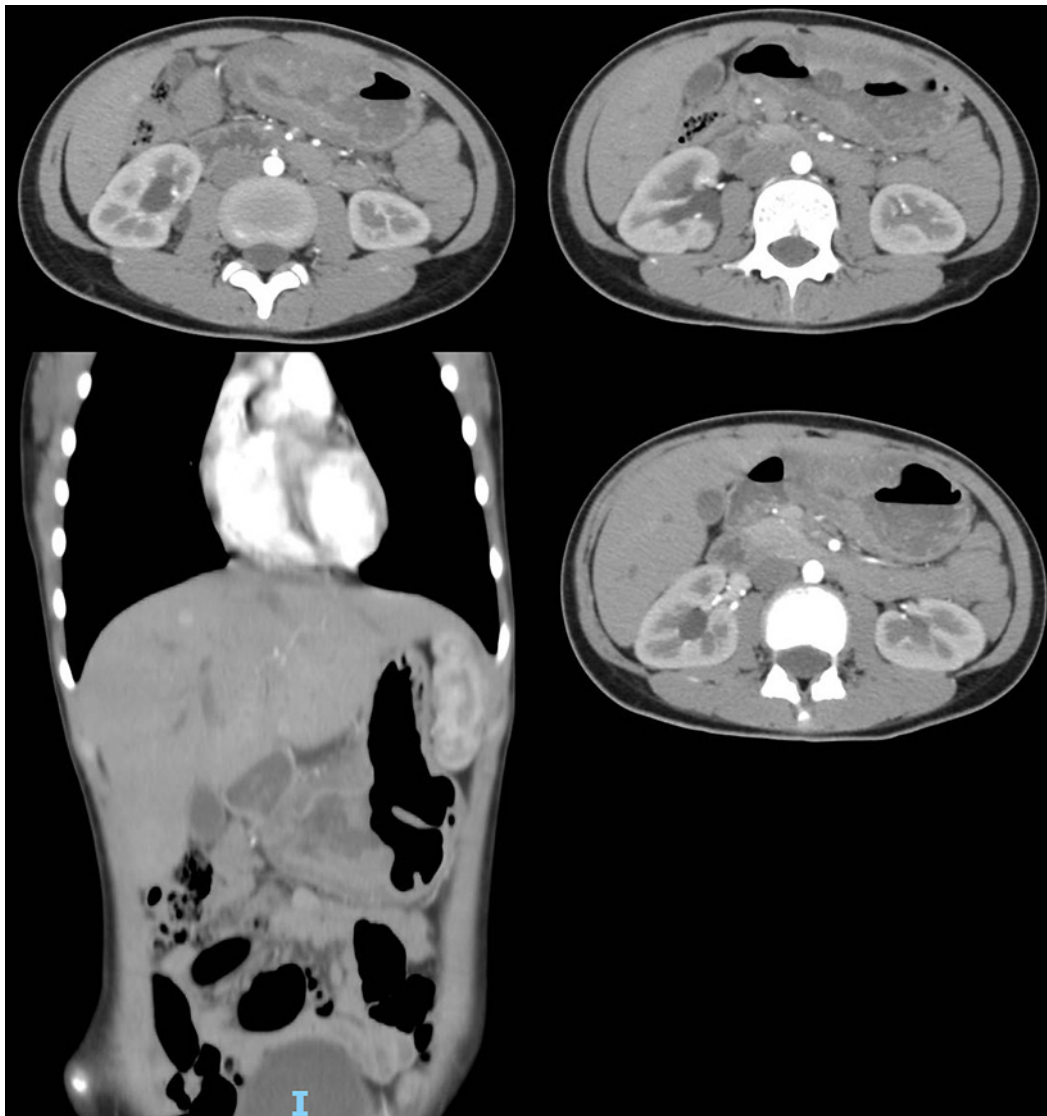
CT-scan images at diagnostic time.
